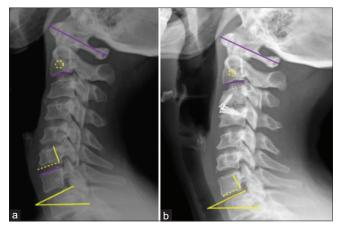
(a) Preoperative cervical spine X-ray profile showing the measurement of lordosis of the C2–C7 segment (-5° in this case), the T1 slope (26° in this case), and the C2–C7 sagittal vertical axis (-5 mm in this case). (b) Postoperative cervical spine X-ray profile at 5 years of follow-up from a C3–C4 anterior cervical discectomy with fusion showing the measurement of lordosis of the C2–C7 segment (-19° in this case), the T1 slope (27° in this case), and the C2–C7 sagittal vertical axis (0 mm in this case)
